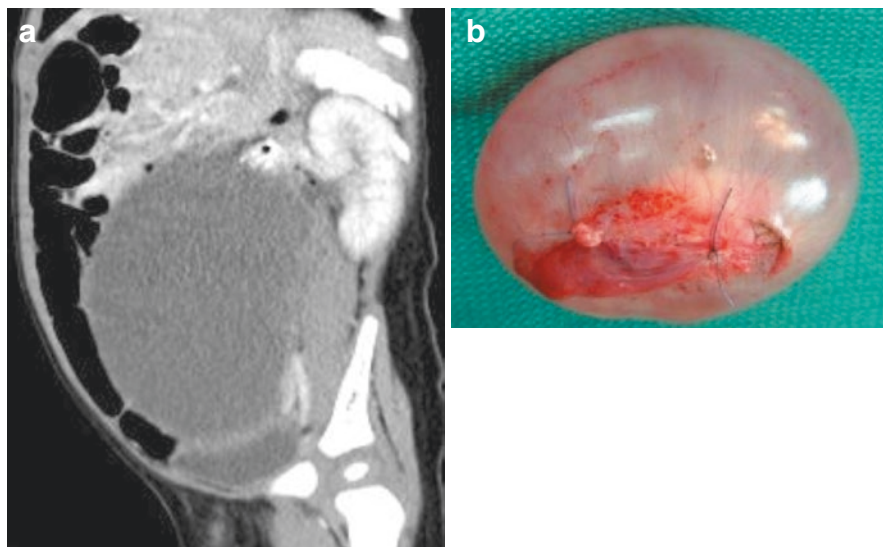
(a, b) Abdominal CT-scan and a clinical photograph showing large ovarian cyst that was completely excised
